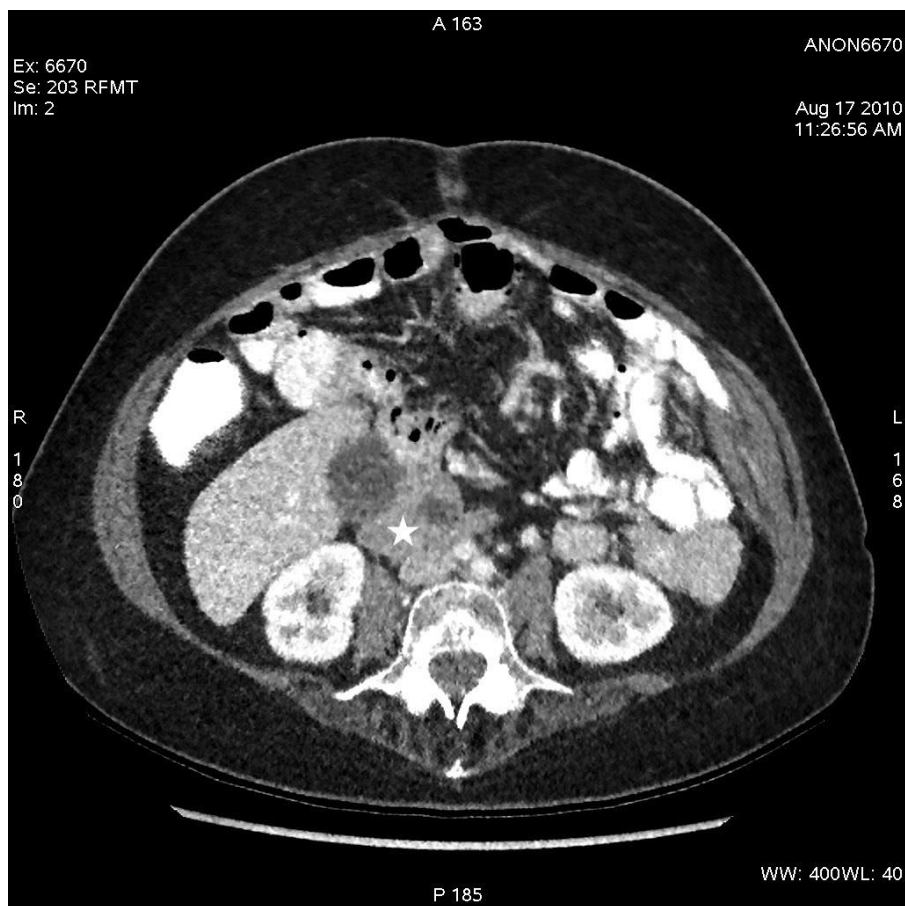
Axial reconstruction of modified dose CT of the abdomen and pelvis with MBIR of a 41 year old lady with a BMI of 29.4 kg/m^2 . The star lies adjacent to a low attenuation lesion within the pancreas that is of indeterminate aetiology. This was an incidental finding and required follow-up imaging of this lesion. This CT study was acquired with a radiation dose of 1.4 mSv .
